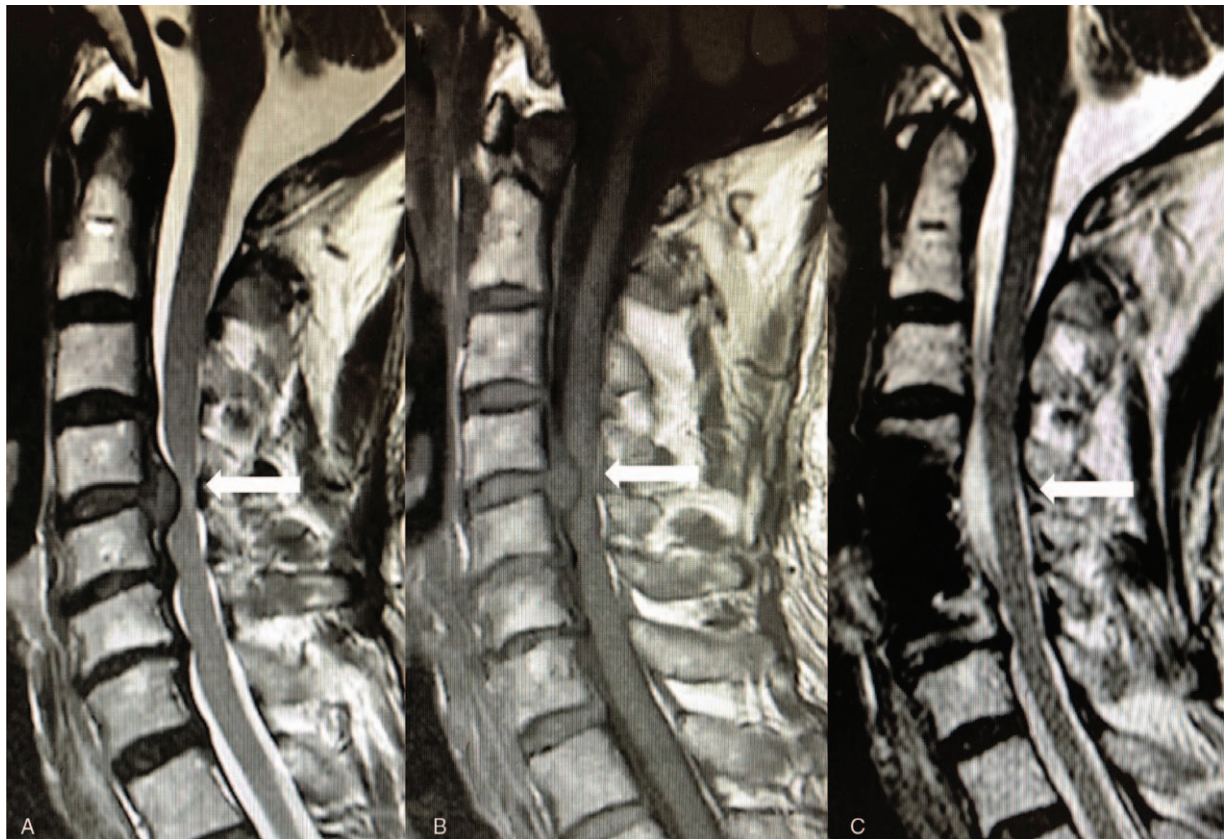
A 53-year-old male CSM patient with anterior compression at C4/5 and C5/6 (A). Duration of symptoms was 14 months at the initial visit. ISI was observed at C4/5 level on T2W MR images (a, white arrow). No sign of decreased signal intensity was found on T1W MR images (B). At the final follow-up (25-month post operation), remaining ISI was noticed on T2W MR images (c, white arrow). CSM = cervical spondylotic myelopathy, ISI = increased signal intensity.
